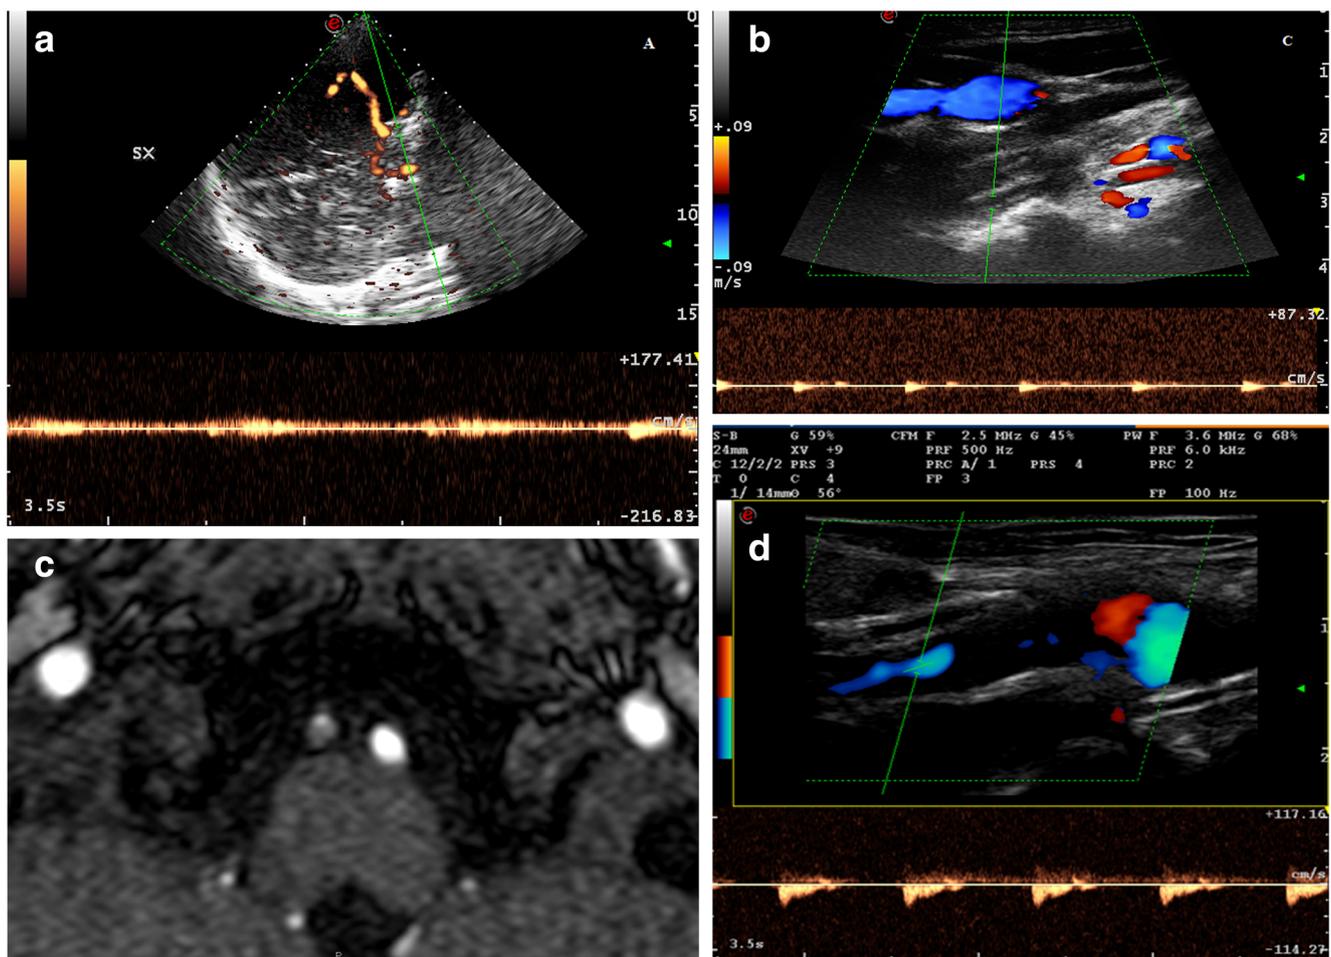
a Transcranial color-coded duplex sonography (TCCD), occipital window: the right vertebral artery in the intracranial tract appears badly detectable except for a colorimetric spot. In its distal tract, it shows a spectrum with very low velocity and high turbulence (patient 1). b Echo color Doppler of supra-aortic vessels: an holosystolic with low-velocity spectrum (stump flow) is detectable in V2 tract of the right
